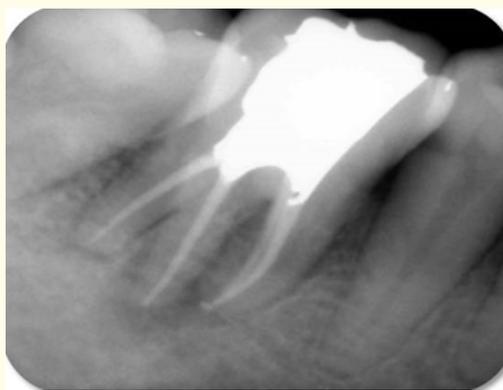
Post obturation IOPA radiograph of tooth #46 with distal angulation.
